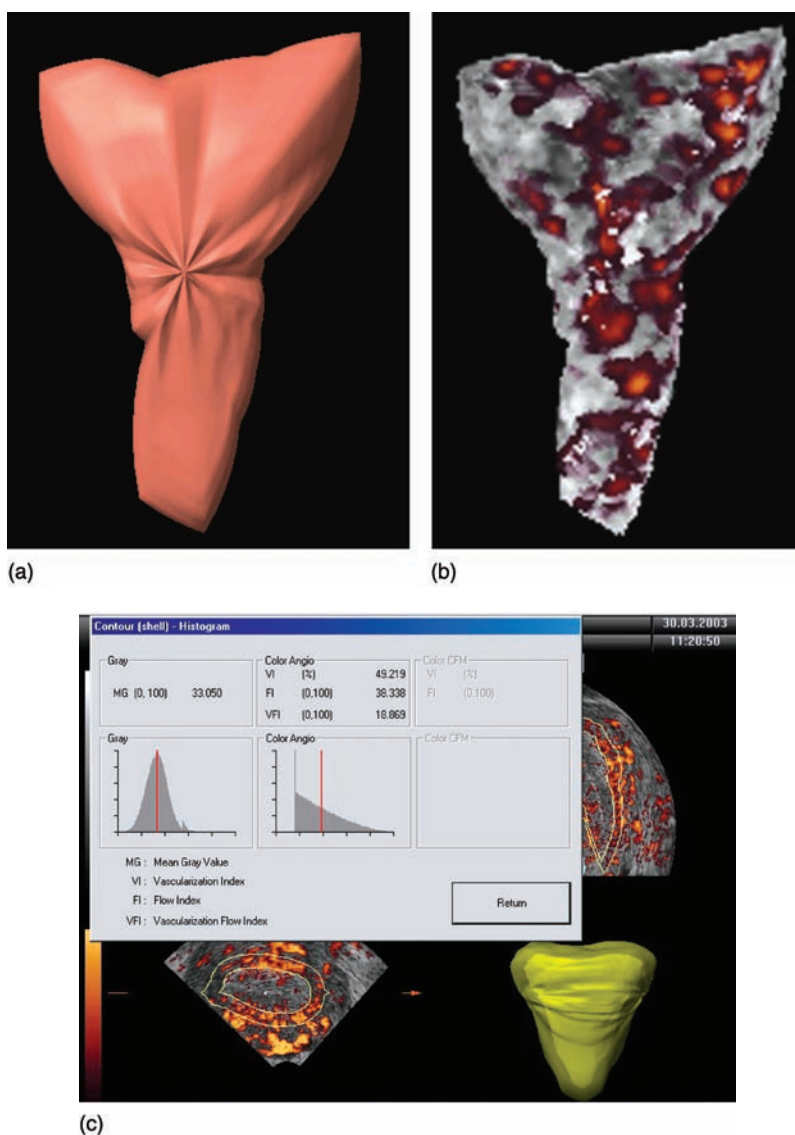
Three-dimensional ultrasound and power Doppler angiography of the endometrium and its vascularity on the day of hCG administration. (a) Endometrial volume by 'skin' rendering. (b) Three-dimensional power Doppler mapping of the endometrial vasculature. (c) Technique of 'shell' to calculate subendometrial 3D power Doppler vascularity indices.
